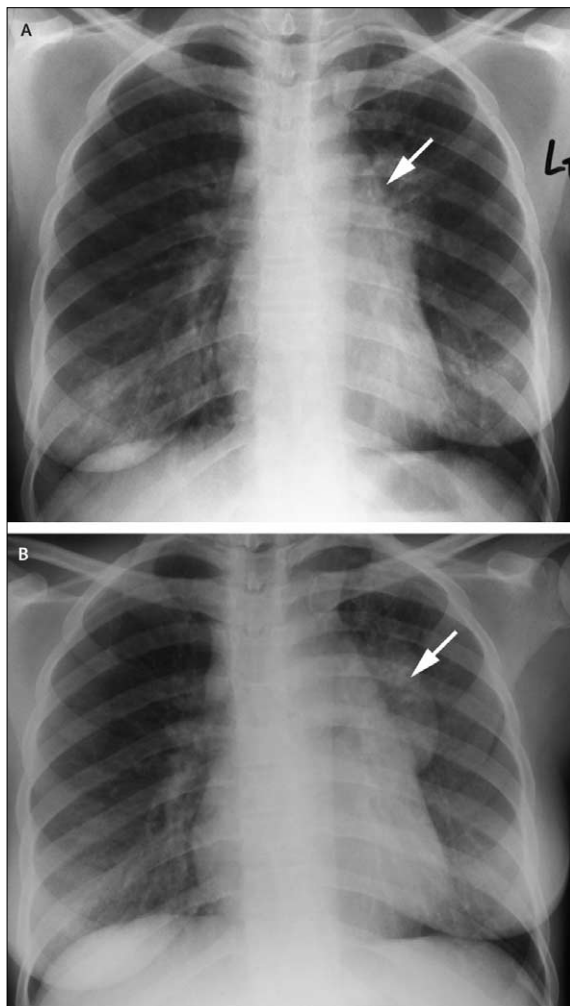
(A) Chest radiograph of an HIV-infected patient at the time of starting HAART showing minor left hilar and aortopulmonary lymphadenopathy (arrow). (B) 17 days after starting HAART, massive mediastinal lymphadenopathy (arrow) and a nodular infiltrate in the mid and lower zone developed due to IRD associated with *M avium* infection. Reproduced from reference 70 with permission from W B Saunders.
